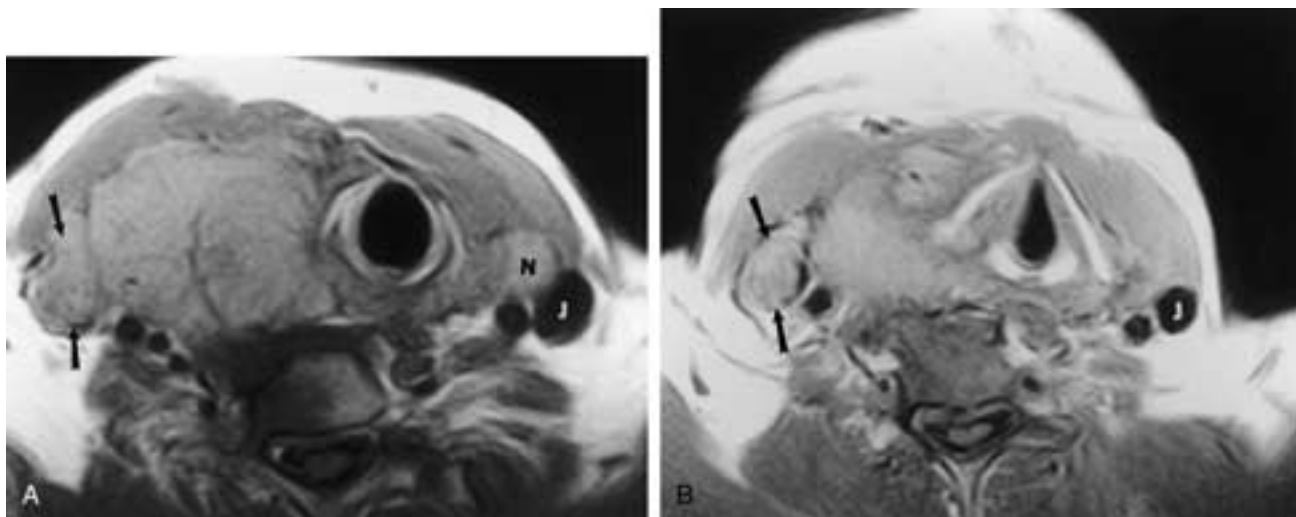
A 68-year-old man presented with a rapidly enlarging right neck mass and facial swelling. MR imaging revealed a right thyroid tumor with extension to the jugular vein. A, Unenhanced axial T1-weighted MR image shows a poorly defined mass originating in the right thyroid lobe with extracapsular extension and direct invasion of the jugular vein, which is filled with tumor (*arrows*). *J*, Left jugular vein with normal flow void; *N*, metastatic disease. B, Unenhanced axial T1-weighted MR image superior to A shows tumor in the right jugular vein.
